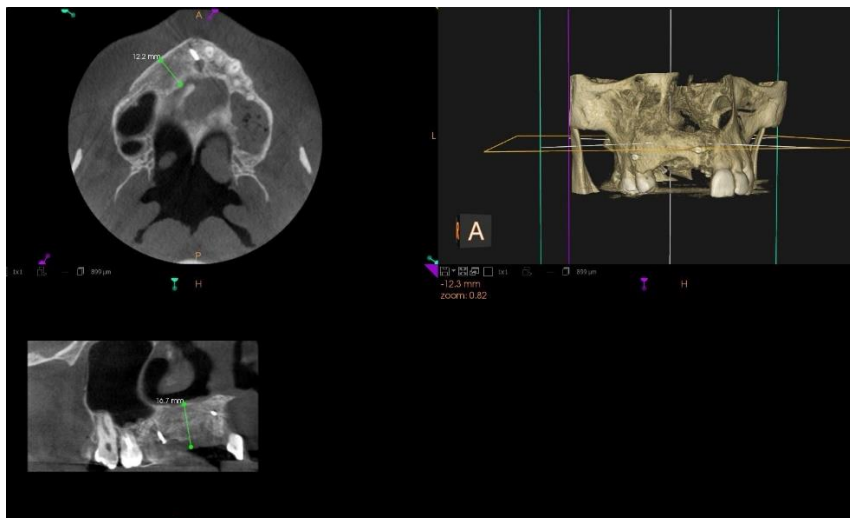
CBCT after about 6 months.
